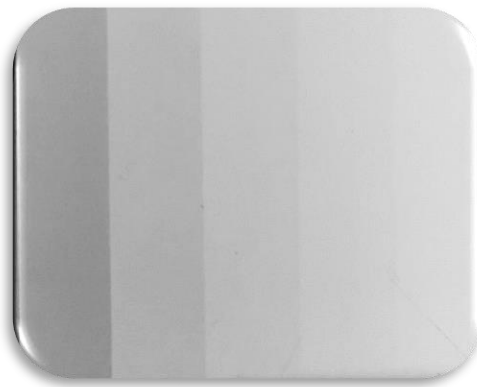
X-ray of the aluminium step-wedge used in determining the materials radio-opacity (thicker step on the right)
